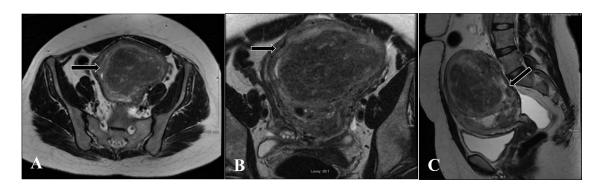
T2 weighted MRI of abdomen and pelvis demonstrating large submucosal uterine fibroid (black arrow) prior to embolization: axial (A), oblique coronal (B), and sagittal views (C).
